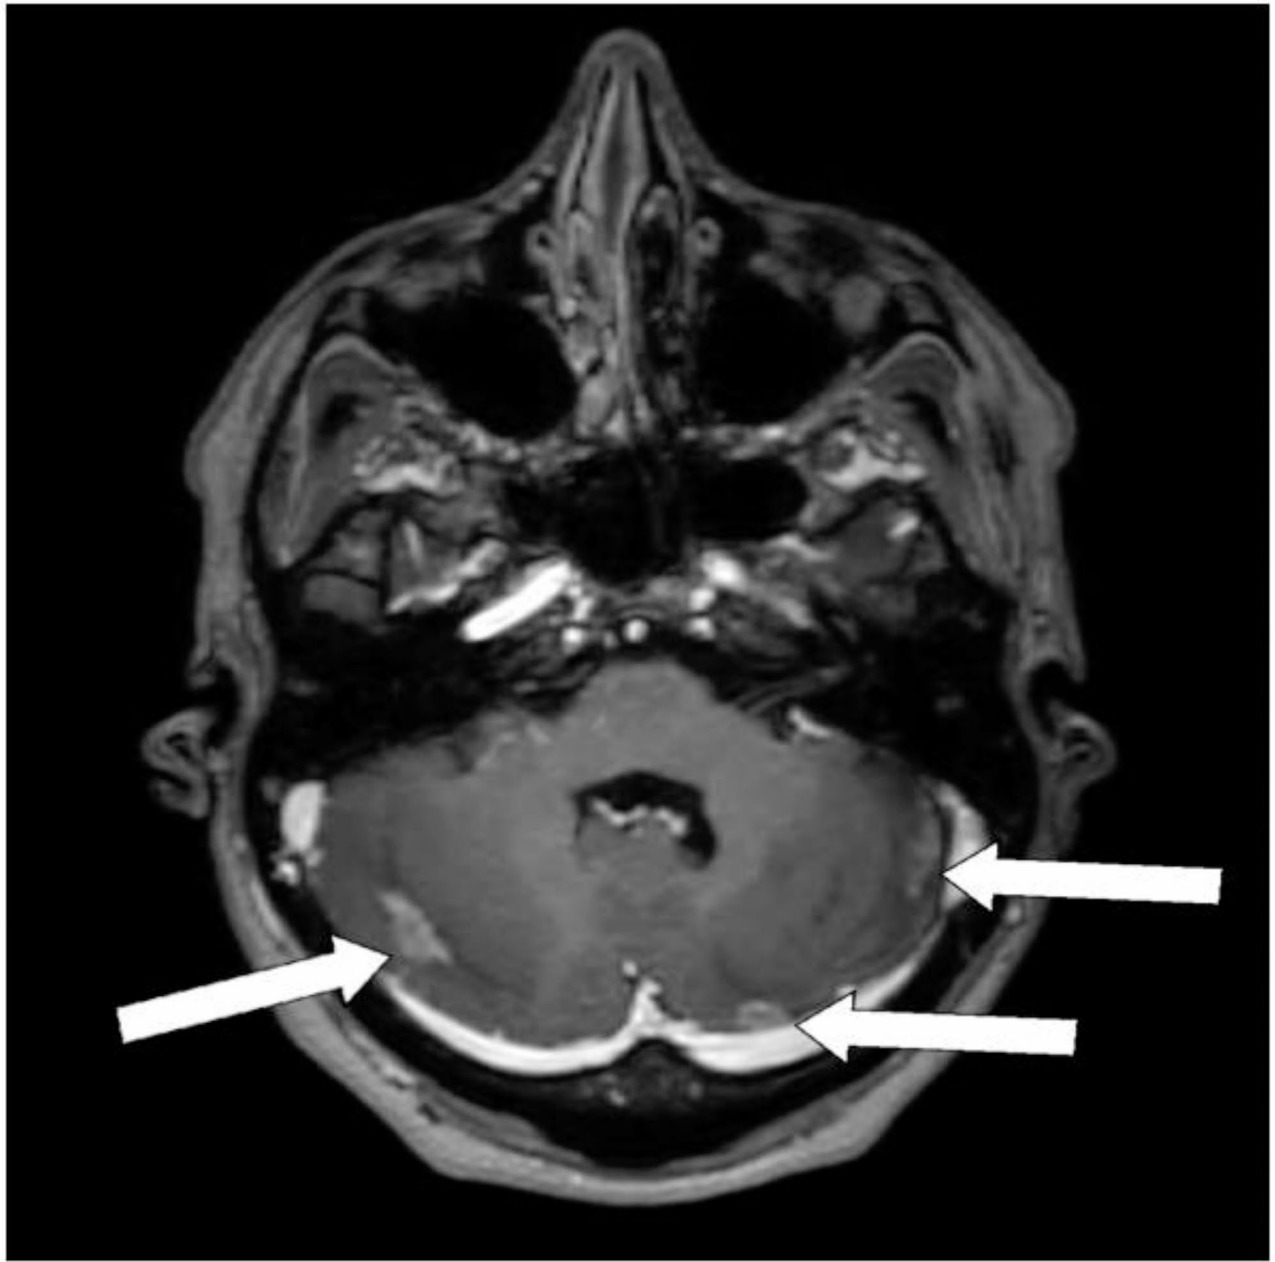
MRI T1 with Gd. 52 year old Breast cancer patient. She was presented with cerebellar progression disease (White arrow), 13 months after whole brain radiotherapy.
